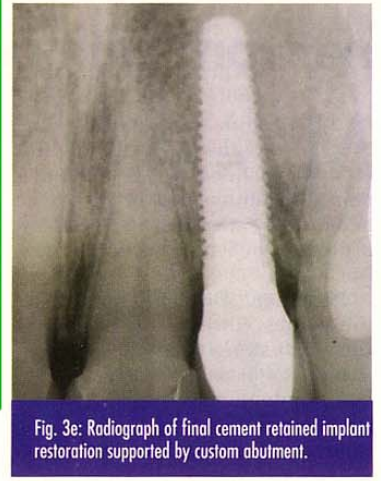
Radiograph of final cement retained implant restoration supported by custom abutment.
